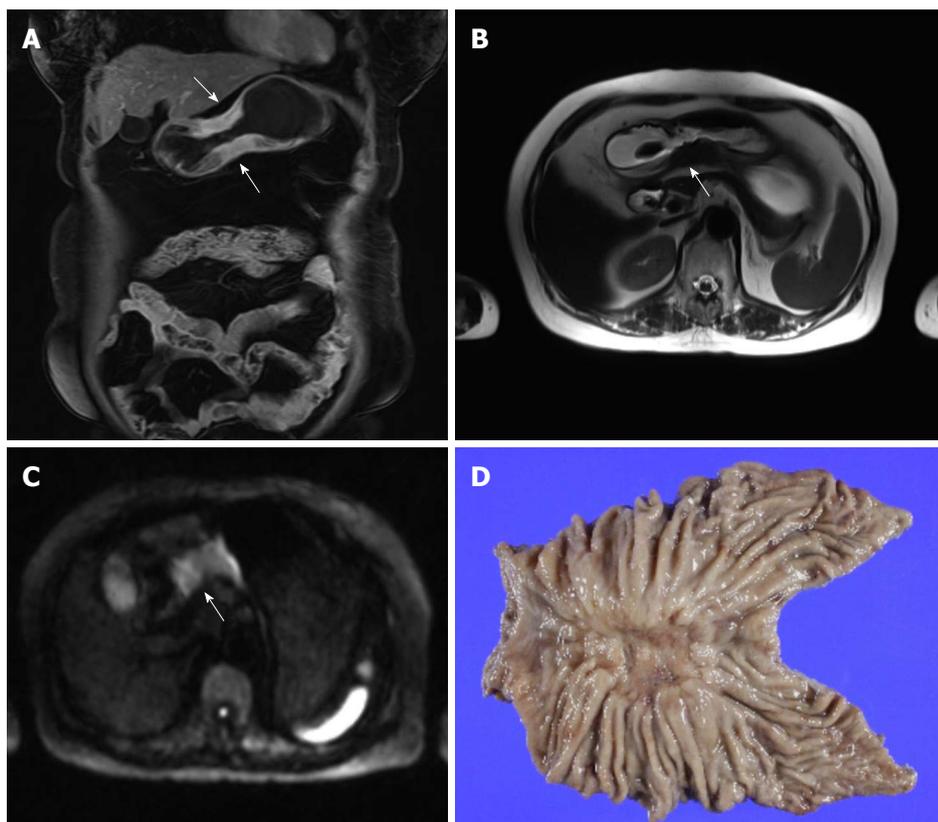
Magnetic resonance imaging of gastric cancer in a 71-year-old female patient. A: Coronal image of contrast enhanced magnetic resonance imaging (MRI) shows enhancing wall thickening of the gastric body (arrows); B: T2-weighted image delineates a low echoic mass (arrow) destroying layers of the gastric wall. The outer border of the mass is irregular; C: Diffusion-weighted image with a b-value of 1000 shows a high signal intensity mass (arrow) with diffusion restriction; D: Subtotal gastrectomy was performed, and pathological examination revealed pT3 cancer.
